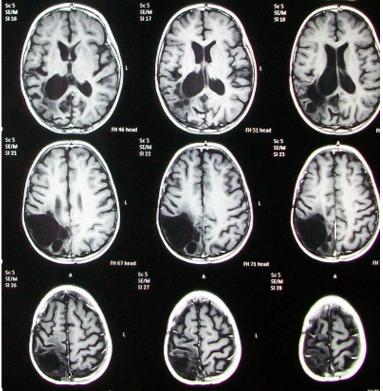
One year postoperative MRI
